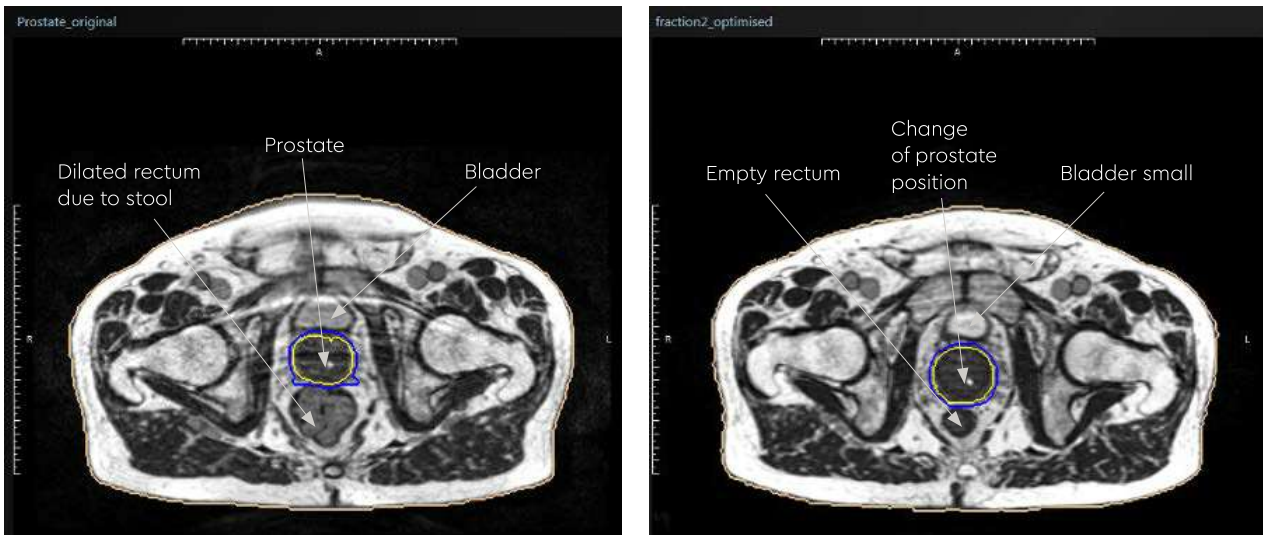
Internal anatomy during the planning MRI
